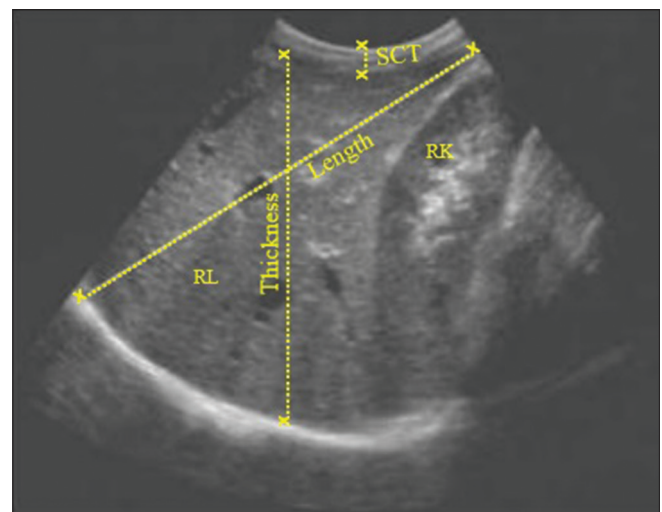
Ultrasound measurements (longitudinal scan) of the liver length, liver thickness, and subcutaneous tissue thickness. RL: Right lobe, RK: Right kidney, SCT: Subcutaneous tissue thickness
